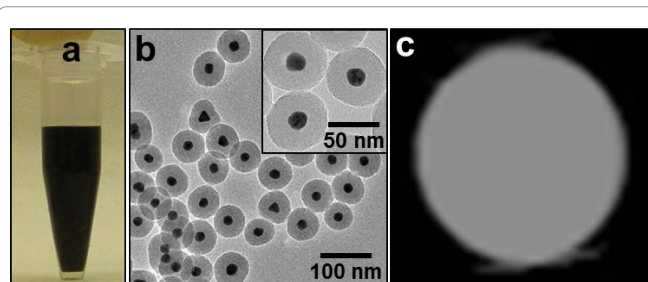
Images of Au/SiO₂/CMC particles. Images (a), (b) and (c) are a photograph of concentrated Au/SiO₂/CMC colloid solution, a TEM image of Au/SiO₂/CMC particles in the concentrated colloid solution, and a CT image of the concentrated colloid solution, respectively.
